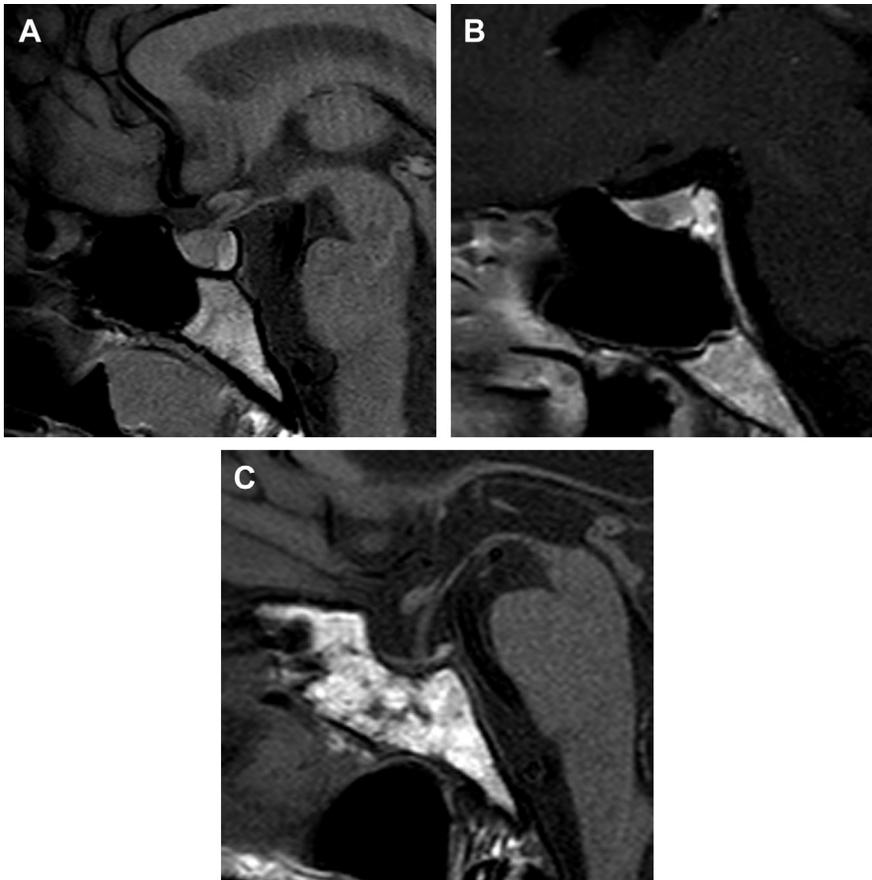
Normal pituitary gland with variations of sphenoid pneumatization. (A) Sagittal T1WI MRI demonstrates a normal size sella within the upper clivus, with normal anterior gland and hyperintense posterior pituitary lobes. The sphenoid sinus is inferior and anterior to the sella. (B) An expanded, hyperpneumatized sphenoid sinus. (C) Arrested pneumatization of the sphenoid sinuses.
